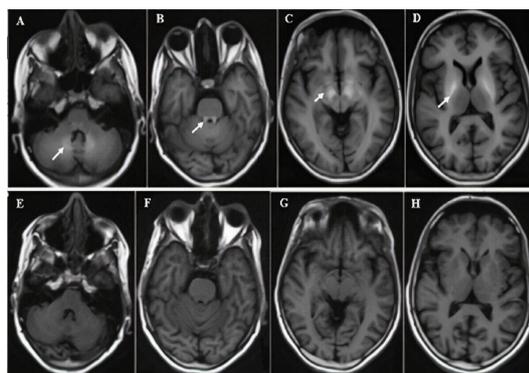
(A–D) T1-weighted MRI shows hyperintensity (white arrows) of the bilateral dentate nucleus of the cerebellum (A), dorsal pons (B), cerebral peduncle (C) and the globus pallidus (D). (E–H) T1-weighted MRI after 2 years of EDTA chelation therapy shows complete resolution of the previous hyperintensities involving the dentate nucleus (E), dorsal pons (F), cerebral peduncle (G) and the globus pallidus (H).
